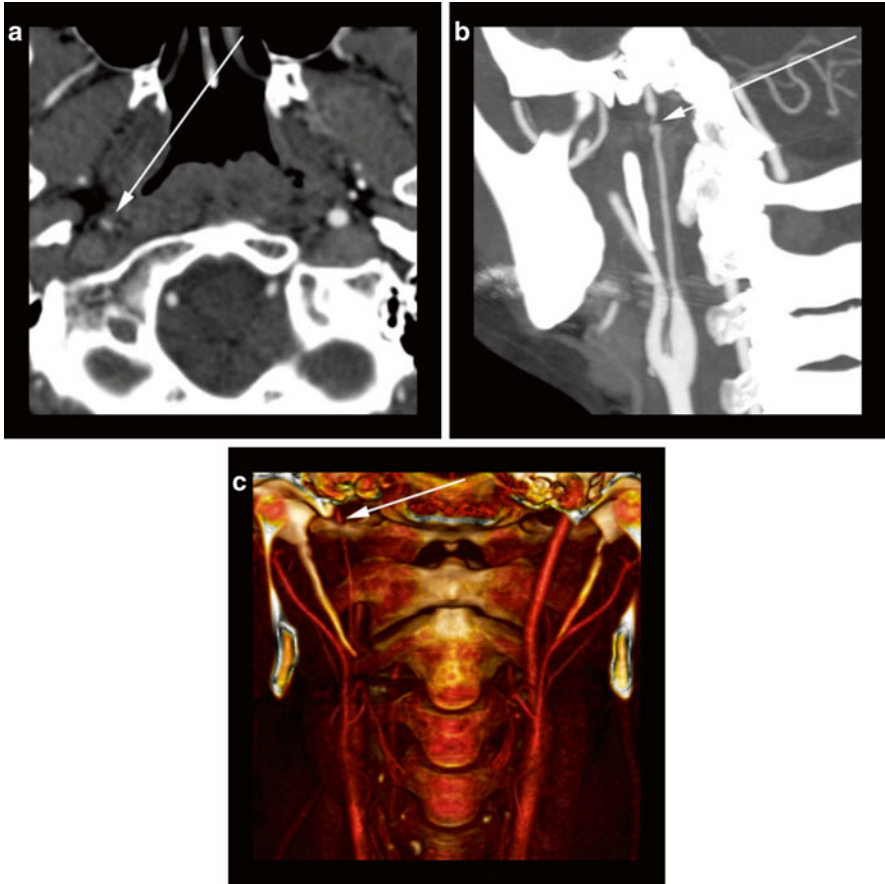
34-year-old female presenting with acute onset of neck pain after motor vehicle accident. (a) Axial CTA image reveals abnormal diminutive caliber (*arrow*) of the right distal cervical internal carotid artery as well as a small focal irregularity suggestive of dissection with small pseudoaneurysm formation. (b) An oblique coronal CTA MIP image better depicts the long segment attenuation of the cervical internal carotid artery as well as the focal luminal abnormality (*arrow*) associated with a severe focal stenosis. (c) A 3D volume rendering of the CTA data also displays the dissection flap (*arrow*) but fine vessel detail is lost due similar density structures along the path of the vessel which is a potential pitfall of VR reconstructions
